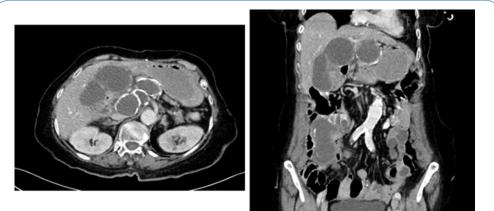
These Computed Tomography images show mucinous masses adjacent to the duodenum and in the right lower quadrant.
